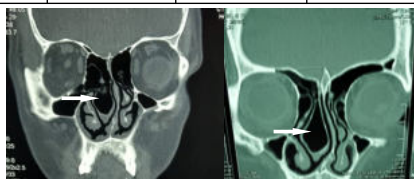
Coronal image of CT paranasal sinus shows unilateral (right) extensive/mixed type of Concha bullosa, with apparent deviation of nasal septum to the opposite side (left).
